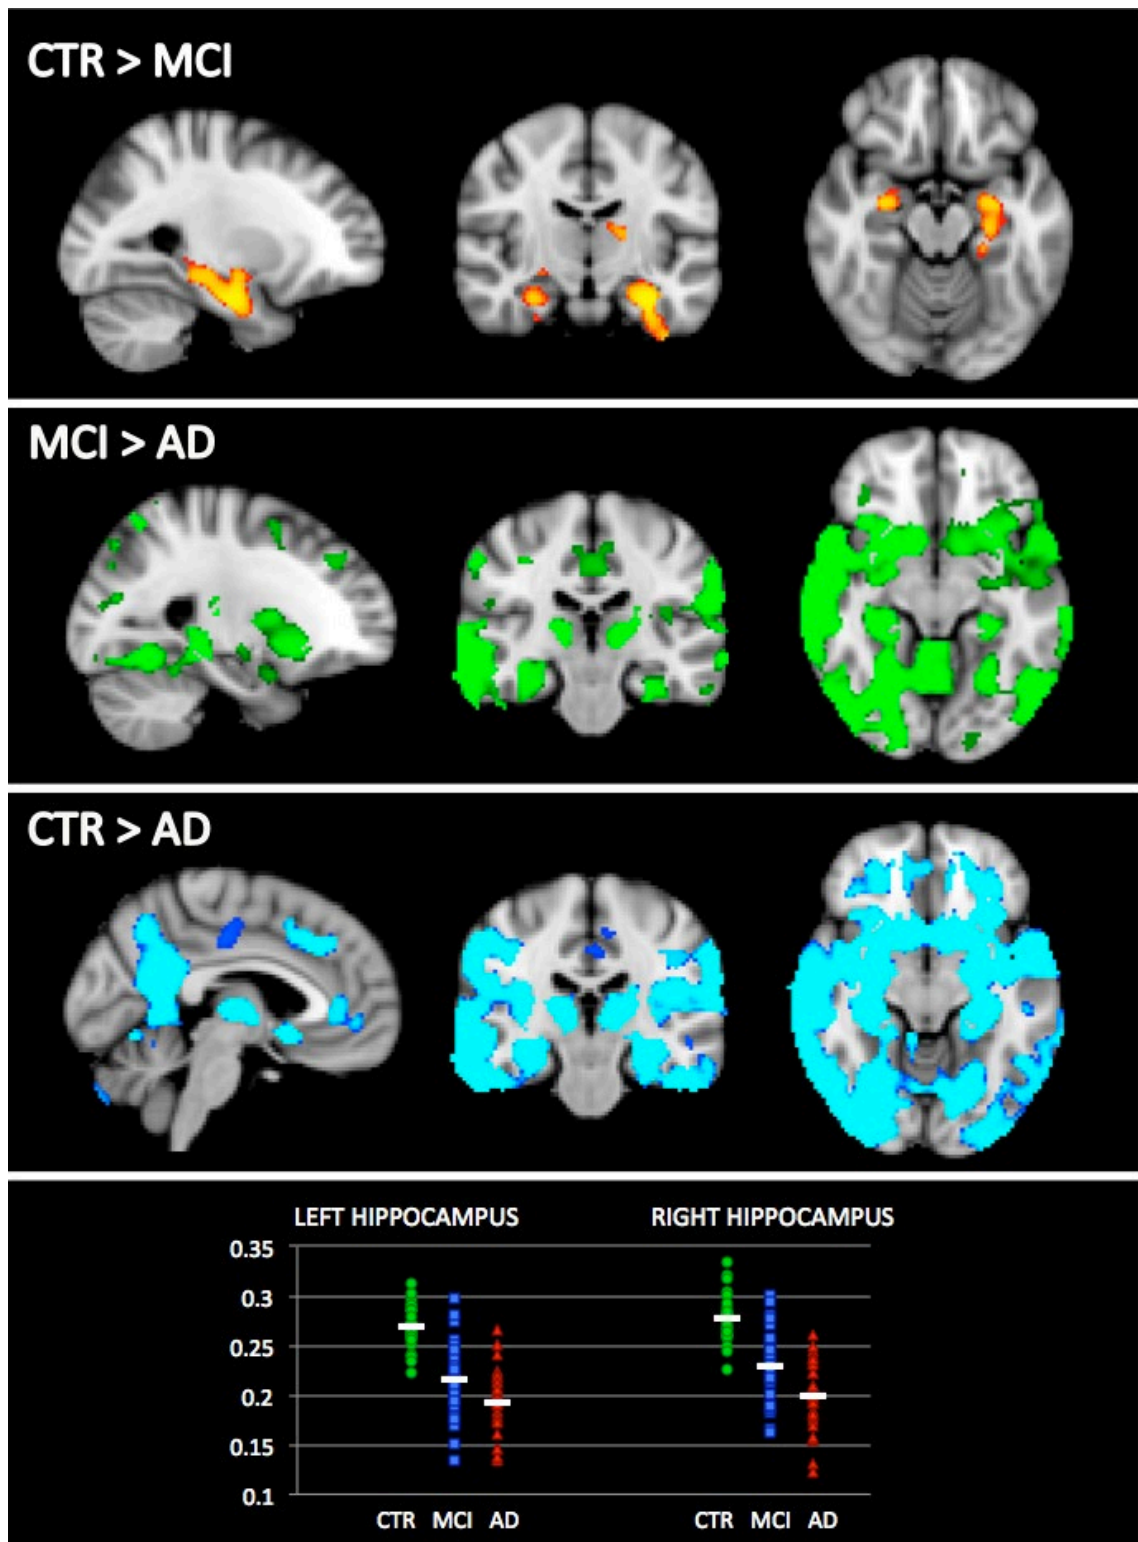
Results of VBM (structural MRI)
